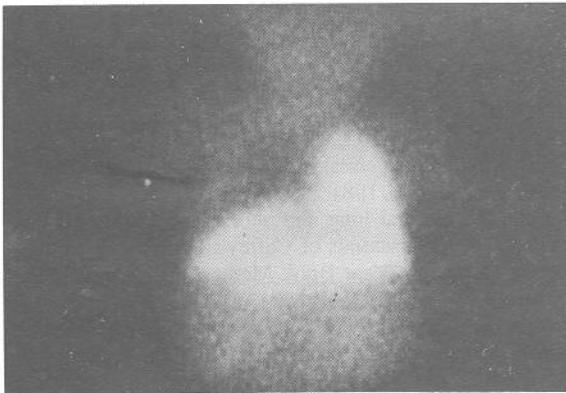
Perfusion scintigraphy in case 2; which shows no uptake in the left hemithorax.
